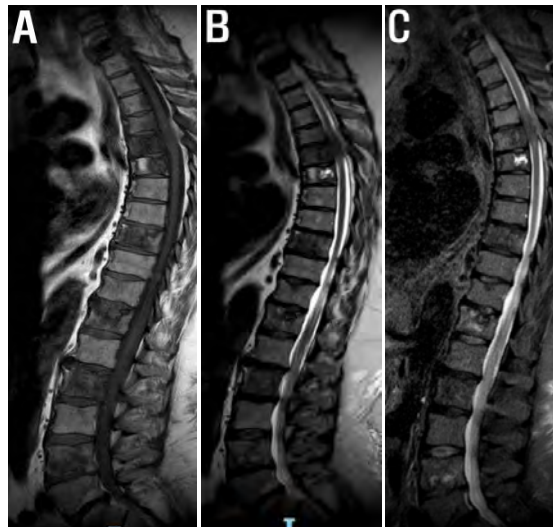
Sagittal full length spine T1 weighted (A), T2 weighted (B) and STIR (C) MR images shows multiple spinal metastasis originating from a prostate cancer.
